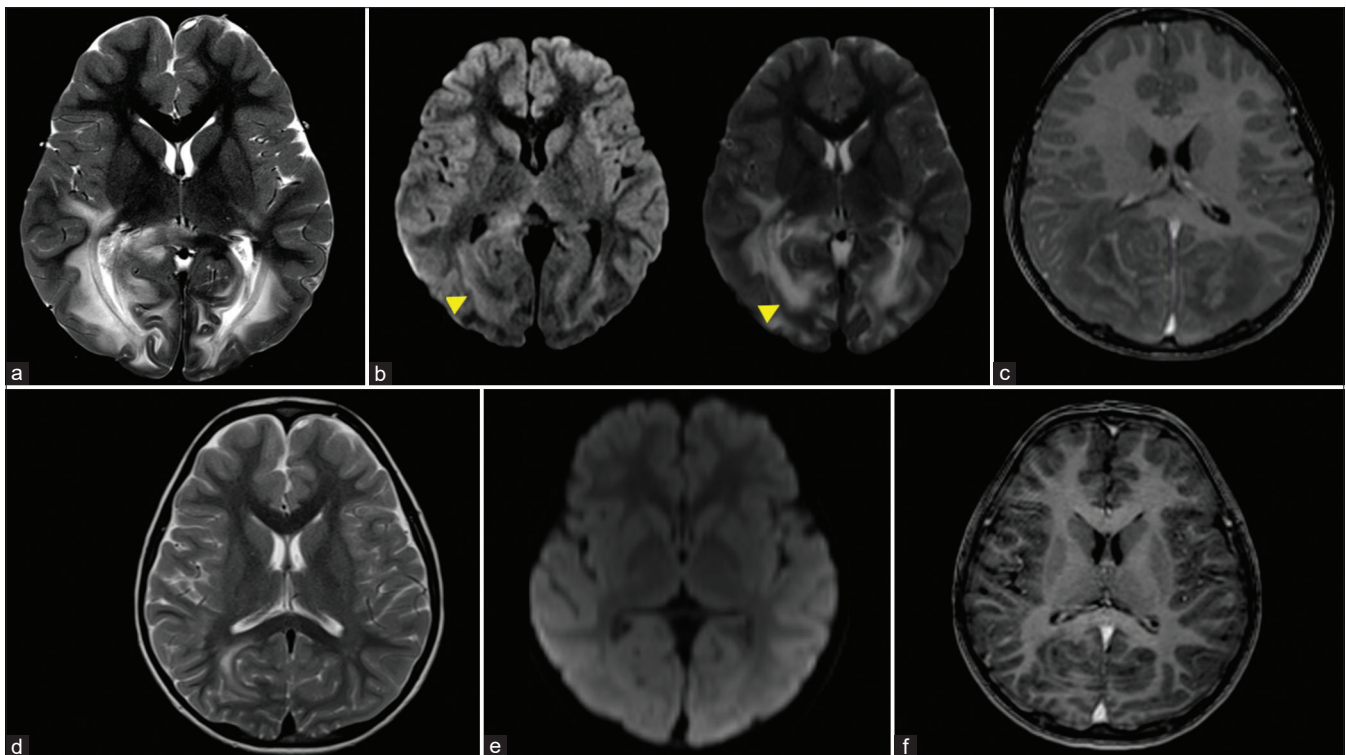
(a) T2-axial image showing bilateral symmetrical confluent involvement of parieto-occipital periventricular and subcortical white matter with extension into the splenium of the corpus callosum. (b) Diffusion restriction brightness (1st panel b) and T1-contrast enhancement (c) were observed at the edge of the lesion, similar to ALD. Note that the areas of diffusion restriction are hypointense on ADC (marked by yellow arrows). (d-f) Follow-up MRI after three months showing near complete resolution of the lesion. ALD: Adrenoleukodystrophy, ADC: Apparent diffusion coefficient
